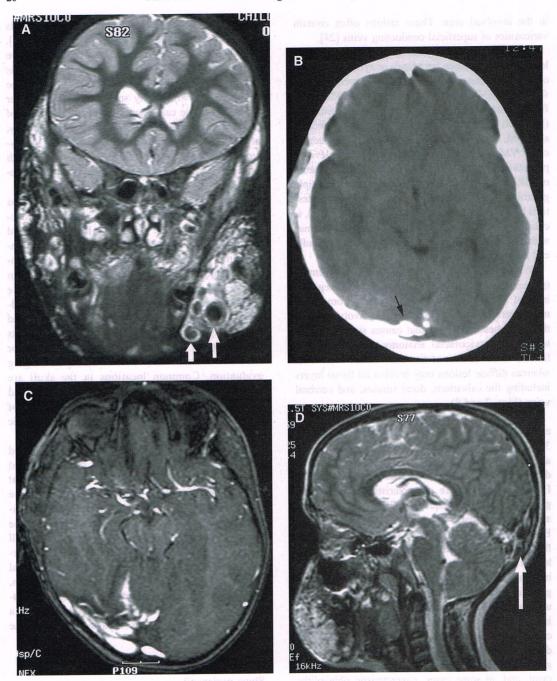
Ten-year-old girl with bilateral cervicofacial VM, anomalous right transverse sinus, and right skull base sinus pericranii. (A) Coronal T2-weighted MR image demonstrates bilateral VM, with phleboliths (arrows). (B) Axial CT image without intravenous contrast medium show calcifications (arrow) in the region of the right transverse sinus. (C) Gradient echo recalled MR image confirms the abnormally dilated right transverse sinus with an intraluminal calcification. (D) Abnormal torcula (arrow) is seen on the sagittal T2-weighted MR image. (E) Left vertebral angiogram, Townes projection, confirms the dural sinus anomalies, as well as cerebellar DVA (arrow).
